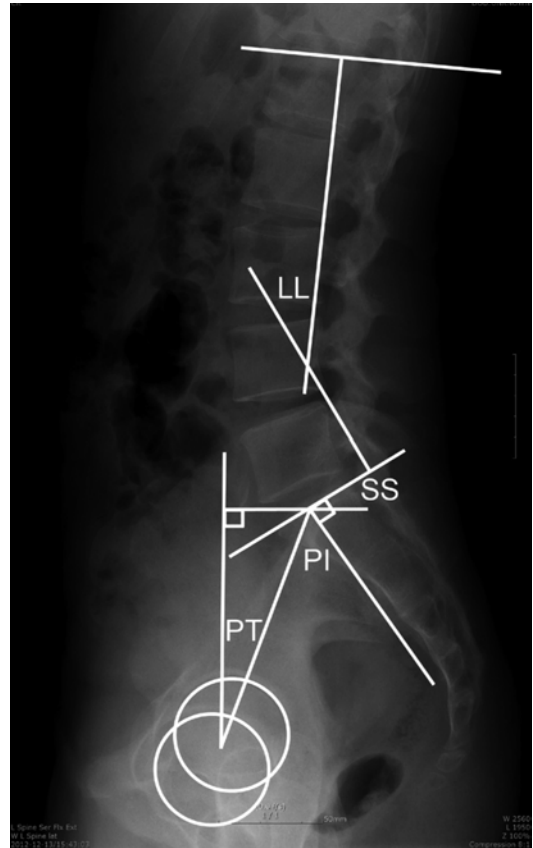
Lumbopelvic spine, lateral x-ray parameters. *LL* lumbar lordosis, *PI* pelvic incidence, *PT* pelvic tilt, *SS* sacral slope [162]
